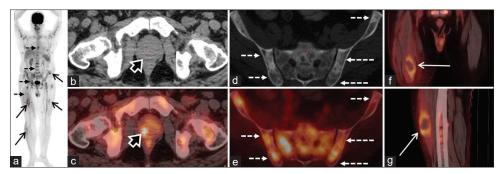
Maximum intensity projection whole-body positron emission tomography image (a) showed multiple foci of increased ¹⁸F-fluorodeoxyglucose uptake in the bones (broken arrows) and muscles (arrows). Transaxial computed tomography (b) and positron emission tomography-computed tomography (c) images of the pelvis showed focal ¹⁸F-fluorodeoxyglucose uptake in the right postero-lateral peripheral zone of prostate (bold arrow). Transaxial computed technology (d) and positron emission tomography-computed tomography (e) images also showed ¹⁸F-fluorodeoxyglucose-avid extensive skeletal sclerotic lesions in the pelvic bones (broken arrows). Coronal (f) and sagittal (g) positron emission tomography-computed tomography images of thigh showing organizing hematoma in the right rectus femoris muscle with peripheral ¹⁸F-fluorodeoxyglucose uptake (arrow)
